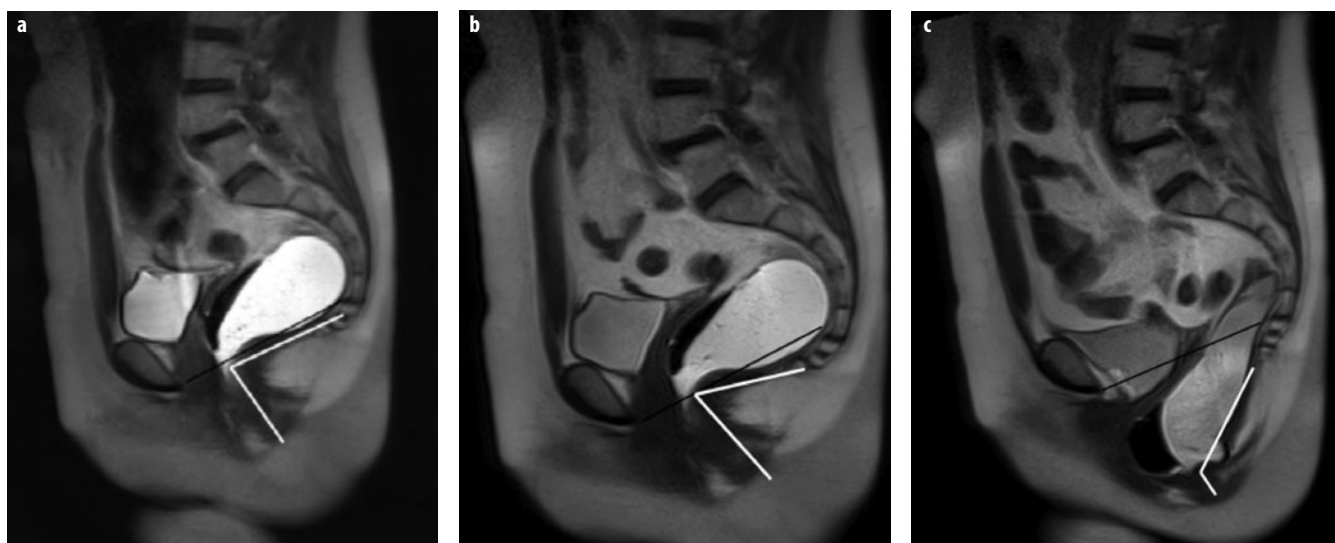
a-c. Anorectal angle variations. a Sagittal T2-weighted image at rest after rectal filling with gel. The pubococcygeal line (PCL) (black line). At rest, the anorectal angle (ARA) (white line) is approximately 85°. The anorectal junction (ARJ) corresponds to the apex of the angle and it is placed at the level of the PCL. b Sagittal T2-weighted image during contraction of the pelvic floor: the ARA (white line) is reduced to <80°. c In this patient with obstructed defecation syndrome (ODS), during straining, the ARA opens >130° due to rectal prolapse (>160°) and is associated with severe ARJ prolapse (>6 cm)
